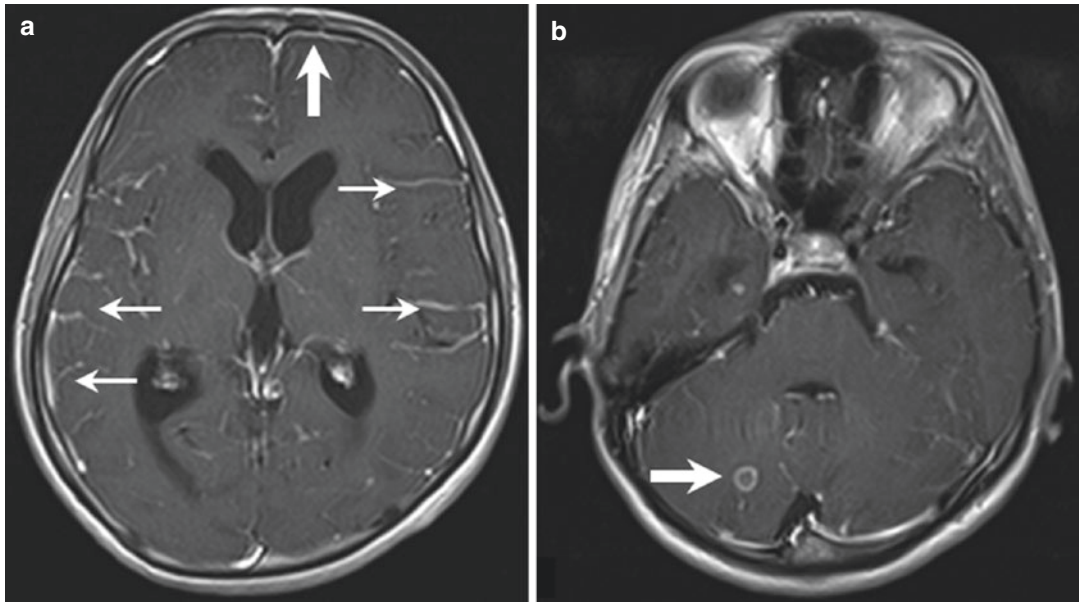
Meningeal TB. (a) Leptomeningeal (*small arrows*) and dural pachymeningeal (*large arrow*) enhancements are seen in this axial post-contrast T1-weighted
